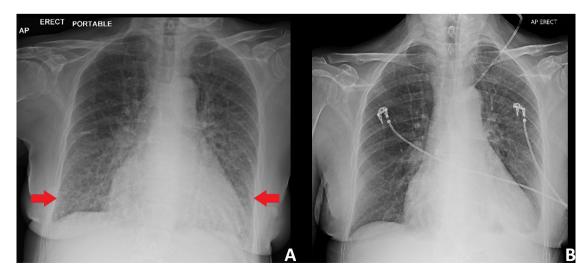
(A) Anterior-posterior (AP) portable chest X-ray demonstrating bilateral interstitial oedema and blunting of the right costophrenic angle. (B) AP chest X-ray demonstrating resolution of interstitial oedema, although blunting of left costophrenic angle now evident.
